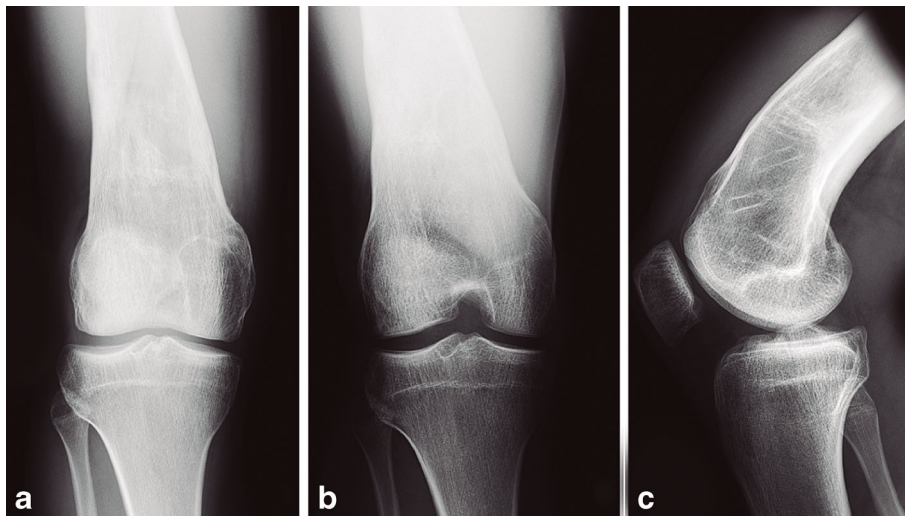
Plain radiographs. a PA view: the image shows a stenotic intercondylar notch. b Flexion PA view. c Lateral view: there is an evident procurvatum in the lateral view.
